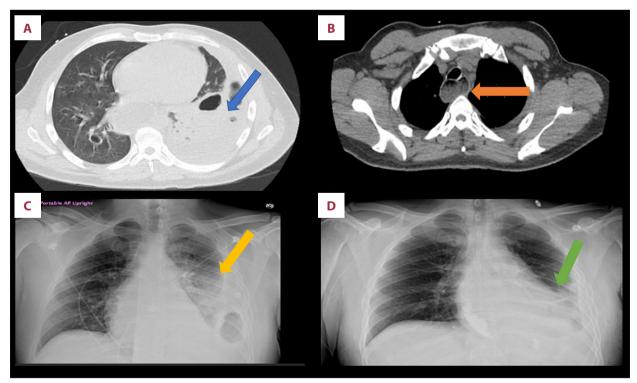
(A) CT of the chest shows empyema on the right lung; Blue arrow indicates empyema of the left lung. (B) CT of the chest showing dilation of distal esophagus; Orange arrow indicates dilated oesophagus. (C) CXR before chest tube insertion showing empyema; Yellow arrow indicated empyema air fluid level before insertion of chest tube. (D) CXR after chest tube insertion showing resolution of empyema; Green arrow indicates interval decrease in the air fluid level.
